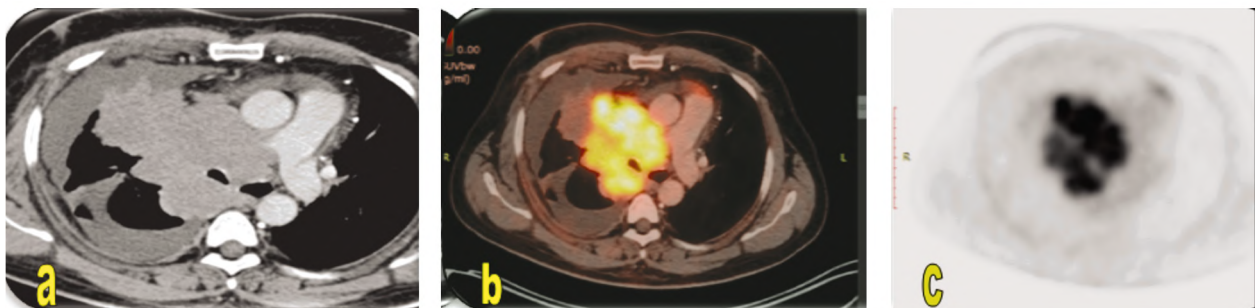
PET CT study for a male patient 50 year old presented with chest pain, cough and respiratory distress. Axial CT Chest with fused PET images (A,B,C) showing large lobulated anterior mediastinal soft tissue mass lesion seen encasing the carina & attenuating the right pulmonary artery with increased FDG Uptake SUVmax=9.9 associated with low grade right pleural and pericardial effusion. PET/CT Diagnosis: Malignant looking lesion. Pathology revealed: High grade poorly differentiated Neuroendocrine carcinoma.
